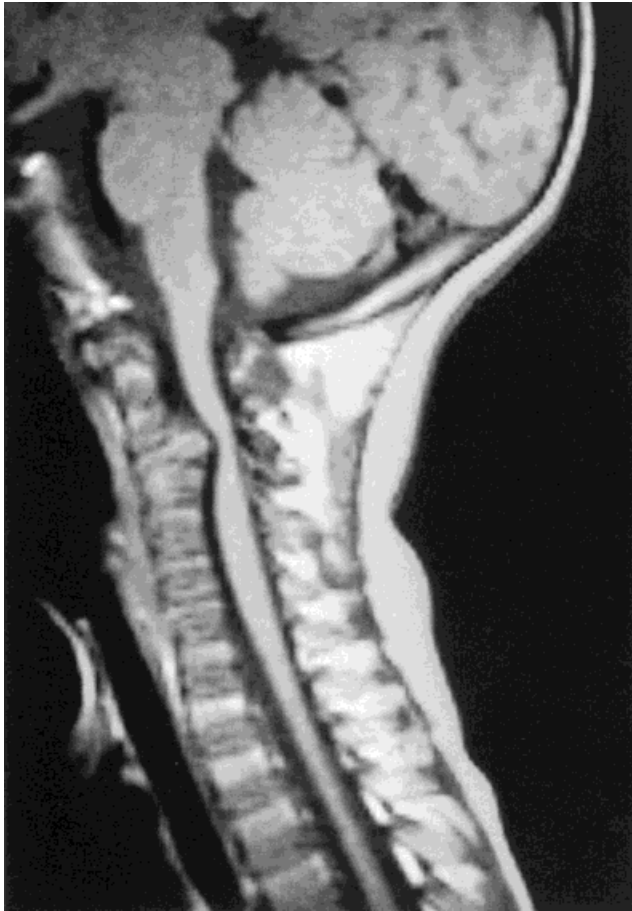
Four-year-old with an unclassifiable form of chondrodysplasia punctata. An MRI of the cervical region shows cervical spine (C<sub>3</sub>) subluxation with cord compression.
